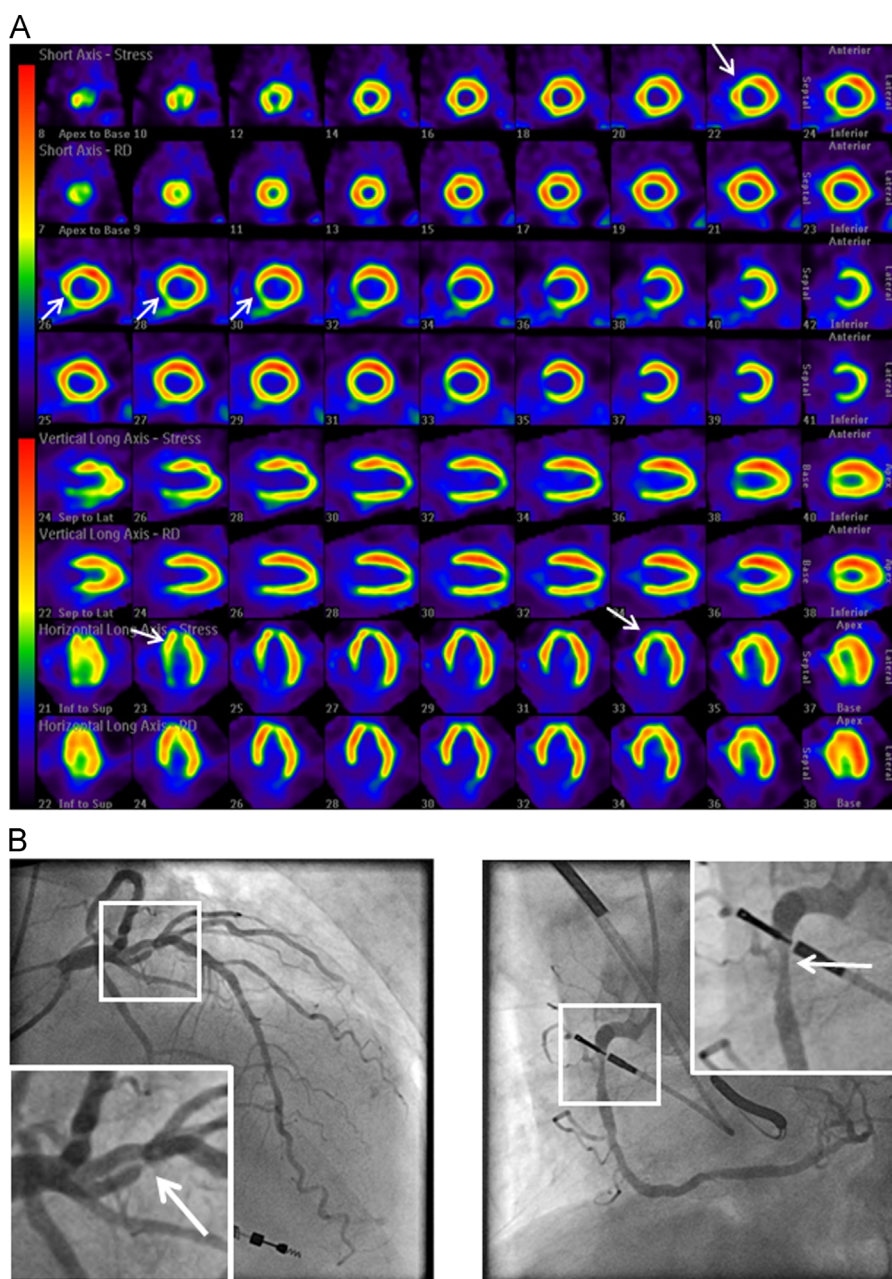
Myocardial ischemia detected by myocardial perfusion imaging using Tl-201:74MBq scintigraphy (A), and coronary angiography for LAD (left) and RCA (right) (B).
